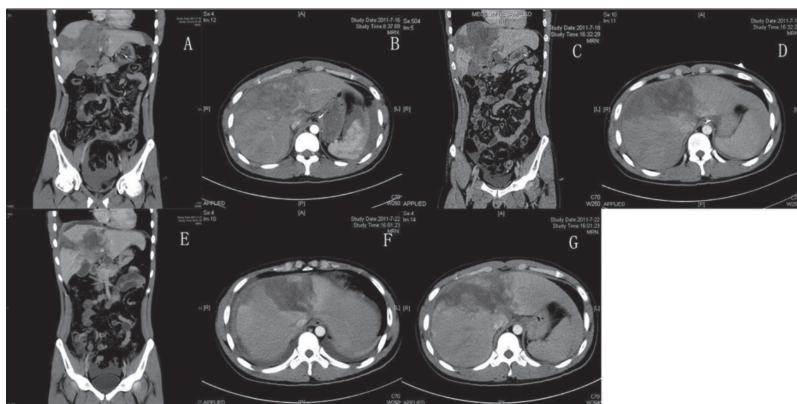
Case 2. A, B – a computed tomography (CT) scan of the abdomen taken four hours after injury demonstrated liver rupture and pulmonary contusions; C, D – a repeat CT scan of the abdomen taken two days after injury; E, F, G – a repeat CT scan of the abdomen taken six days after injury demonstrated that the hematoma in the liver had been gradually reabsorbed with no progression of the lesion
